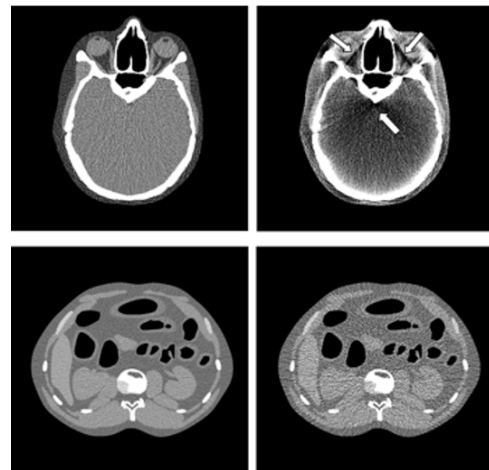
Top: sample transaxial-slice CT images of the head at 80 kVp (left) and 120 kVp (right) showing a beam-hardening artifact (arrow). Bottom: sample noisy transaxial-slice abdominal CT images at 1 mAs/view (left) and 0.1 mAs/view (right).
